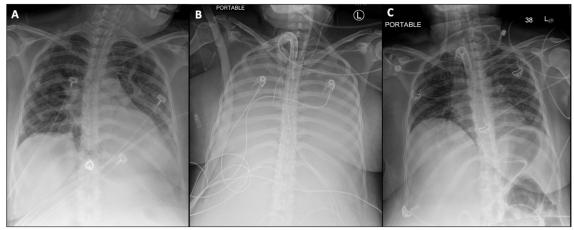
Radiographic progression of chest X-Ray (CXR). A: CXR on admission. B: CXR during left pulmonary alveolar hemorrhage. C: CXR before tracheostomy decannulation.
